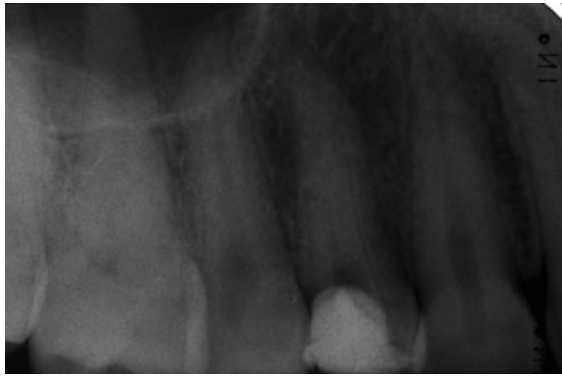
Radiograph taken prior to endodontic treatment, where cusp has been removed.
